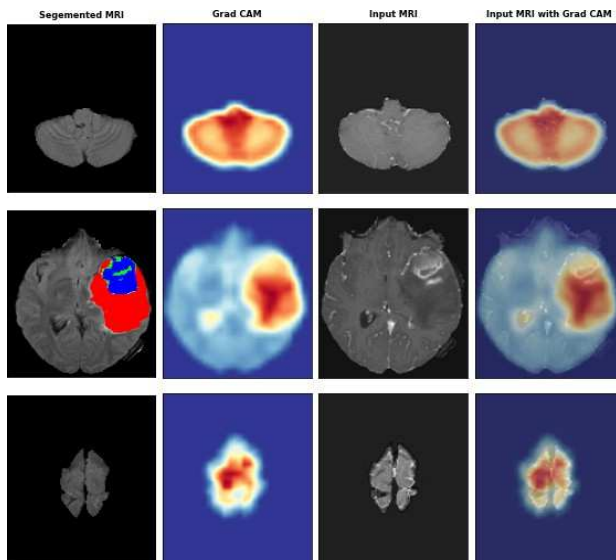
Grad CAM of regions generated at different depths of same MRI volume where tumor exists (row 2) and does not exist from bottom view (row 1) and from top view (row 3) of brain.
